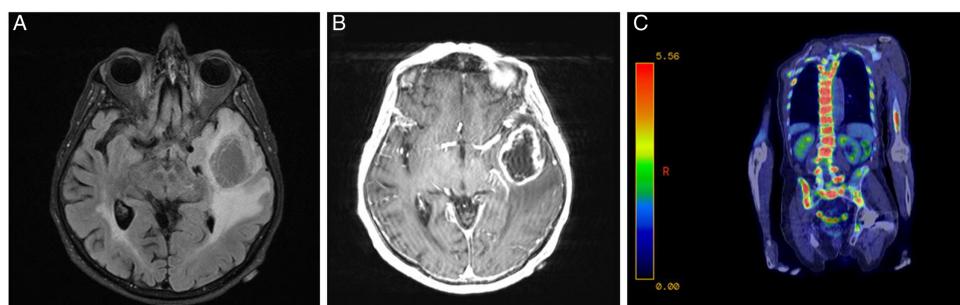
Axial T2 FLAIR MRI of the brain demonstrating a left temporal lobe mass with surrounding vasogenic edema (A) and ring enhancement on MRI of the brain with contrast (B). PET-CT scan showing extensive metastases to the vertebrae and pelvis (C).
